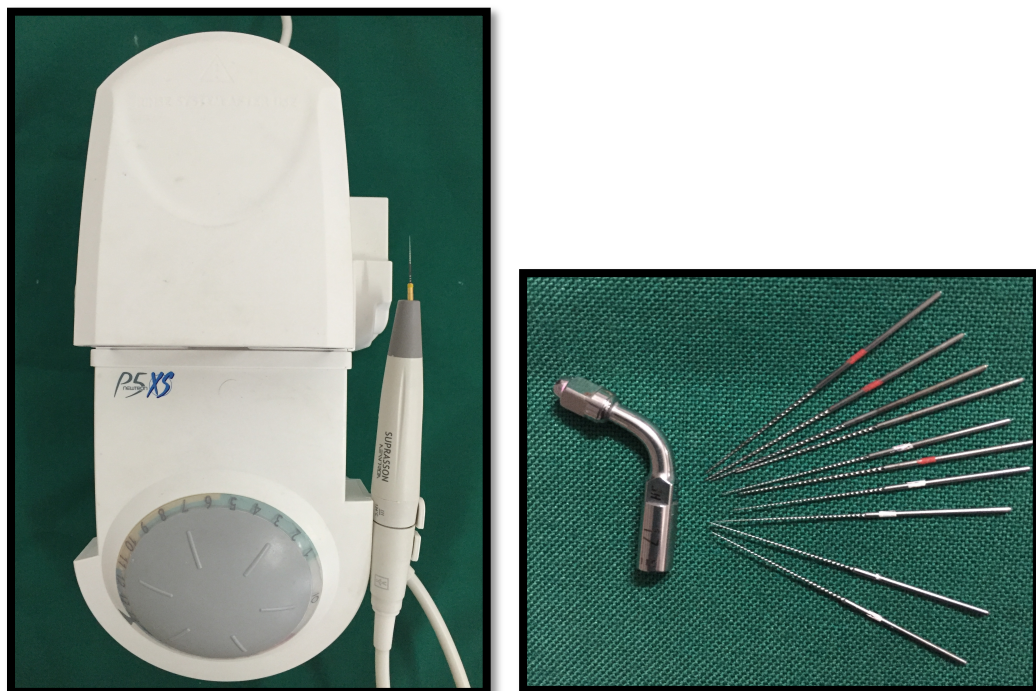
2 SETLEC ultrasonic device with endosonic files
